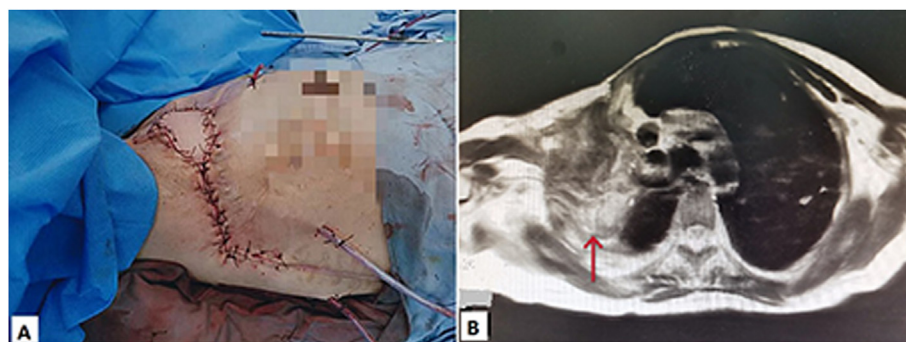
Postoperative images of case-1. A. After surgery, the myocutaneous flap was sutured to normal skin around the chest without tension. B. Postoperative MRI showed the muscle flap completely filled the abscess cavity and the empyema disappeared (red arrow).
